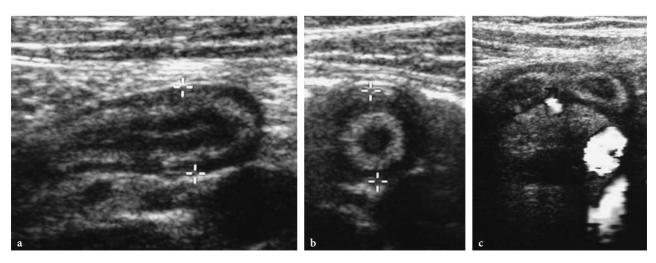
Acute appendicitis in a 12-year-old boy. a Longitudinal ultrasound image showing a swollen appendix (*markers*) which measured 7 mm. Note the increased echogenicity in the wall. b Transverse image (TS) showing the concentric layers of the inflamed appendix. c TS image showing two sections of the curved appendix and it's relationship to the iliac vessels
